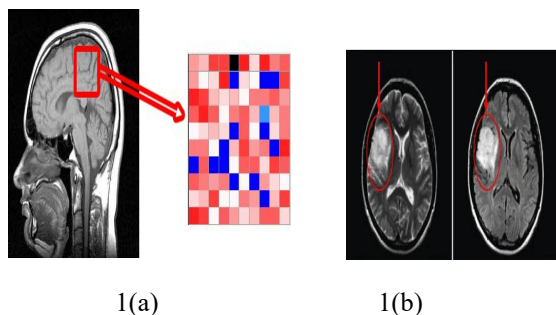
(a) 2D Model of Brain Tumor Detection (b) MRI image of a brain tumor [18]
